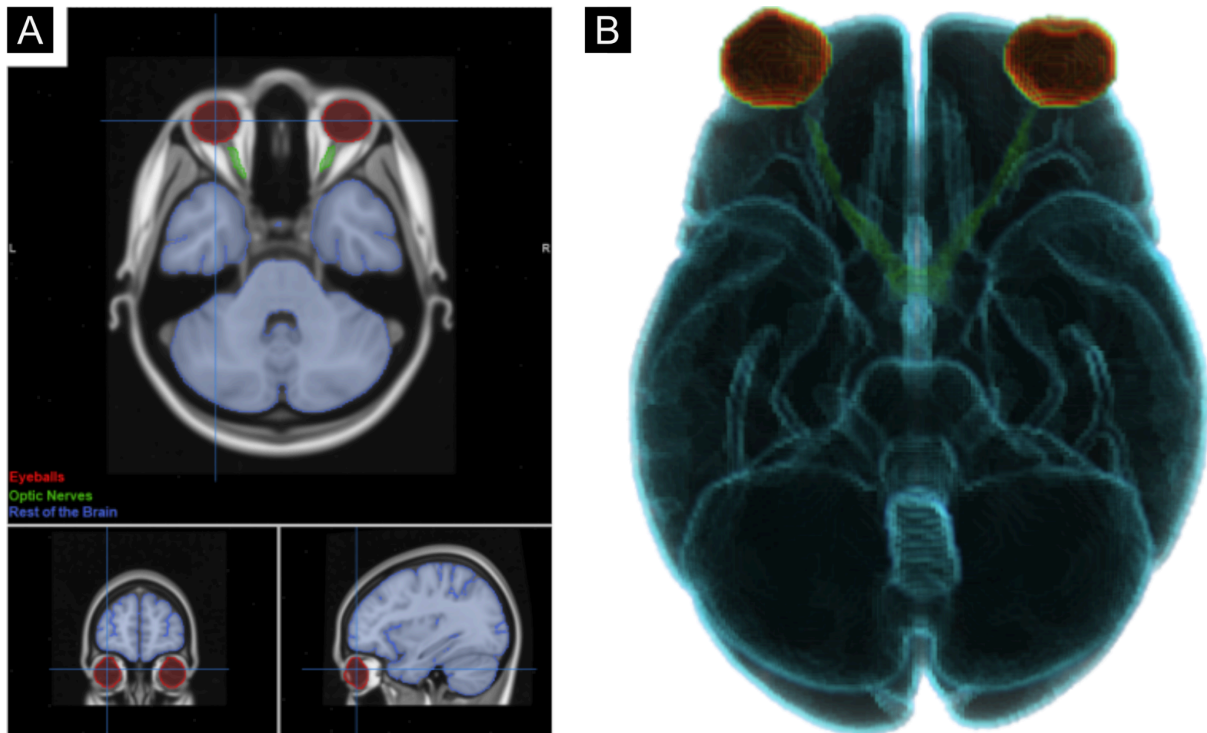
Visualization of regions of interest (ROIs) in the MNI152 template space. (A) The structural MRI image in the MNI152 template space with overlaid ROIs representing different anatomical structures. The ROIs highlight the eyeballs in red, the optic nerves in green, and the rest of the brain's white and gray matter in blue. The three orthogonal views (axial, sagittal, and coronal) provide a comprehensive visualization of these regions. (B) A 3D surface rendering of the same ROIs, showing the eyeballs and optic nerves prominently on the ventral view of the brain, providing spatial context and anatomical relationships in a surface model. The renders were realized using the mayavi library in Python. These ROIs were then used in analyses of the characteristics of the induced electric field (IEF) in each of the three specified areas.
